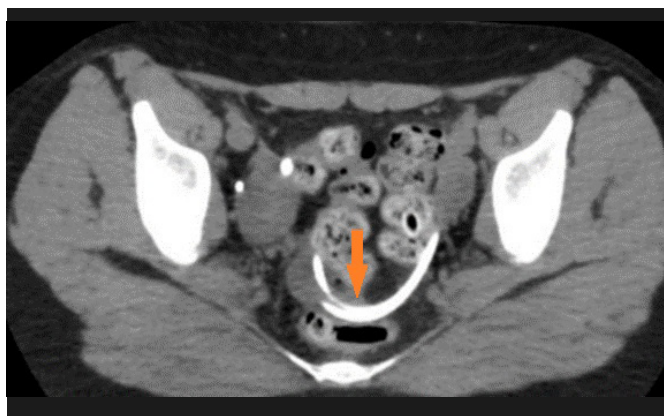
Computed tomography ventriculoperitoneal shunt fragment located in the small pelvis (arrow).
